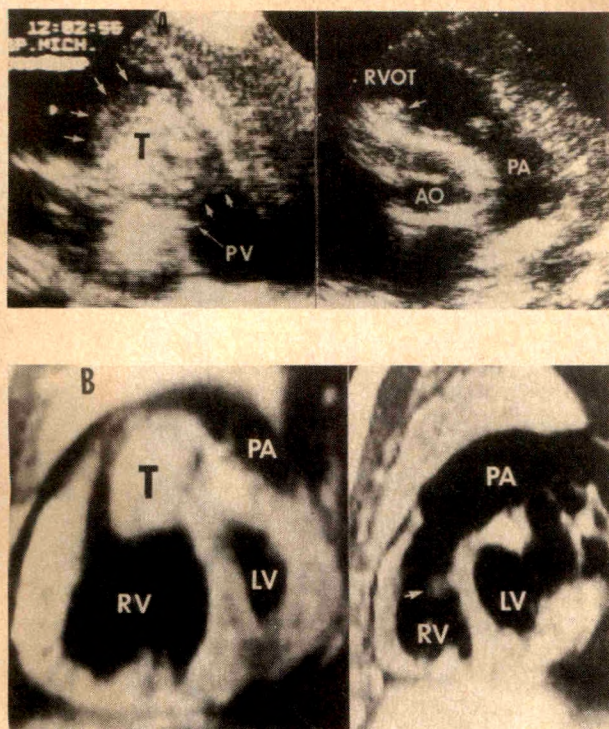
Patient 5. (A) Short-axis high parasternal view obtained at 10 months of age (left) reveals a large rounded mass almost completely occluding the right ventricular outflow tract (RVOT) (arrows). The outer shell of the mass appears nonhomogeneous and less echodense than its central portion. A follow-up study at 17 months of age (right) reveals almost complete resolution of the mass. (B) Magnetic resonance imaging at 12 months of age (left) reveals a large mass in the right ventricular outflow tract. A follow-up study at 18 months of age (right) reveals a minimal residual mass (arrow). (C) Color-flow Doppler study at 10 months of age (left) reveals the bifid pattern of flow around the mass in the right ventricular outflow tract (RVOT). A follow-up study at 17 months of age (right) shows normal flow pattern in the pulmonary artery (PA). Ao = aorta; LV = left ventricle; PV = pulmonary valve; RV = right ventricle; T = tumor.
